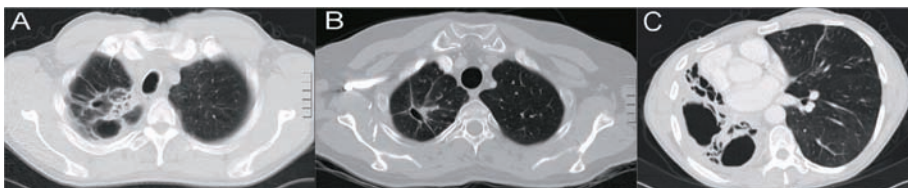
Computed Tomography images of patients who underwent surgical treatment
